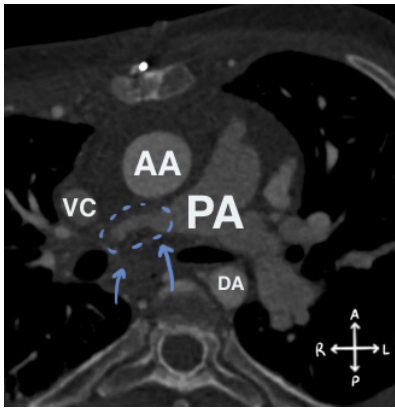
CT scan that shows the disparity in sizes of the left and right branches of the pulmonary artery. The right branch is very small in contrast with the left branch (blue circles and arrows). Axial view.
